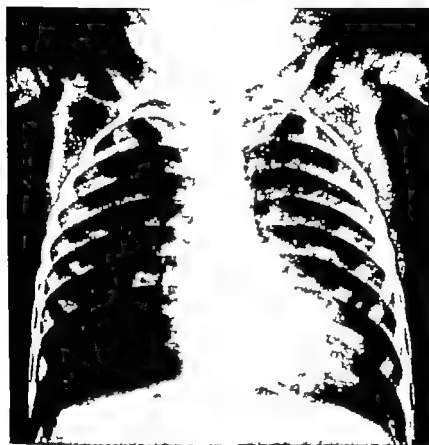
Roentgen film of the thorax in a case of tetralogy of Fallot.
